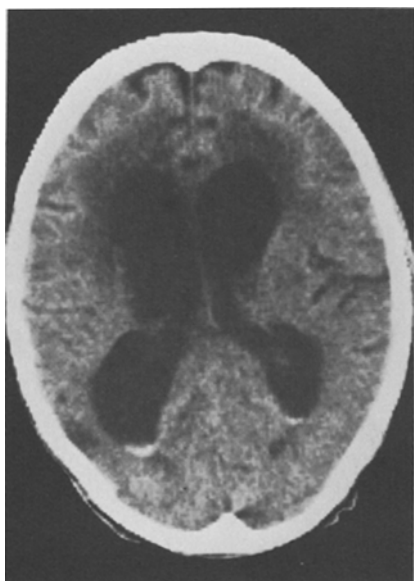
CT (5 months after HZO) shows overt hydrocephalus and intraventricular haemorrhage
